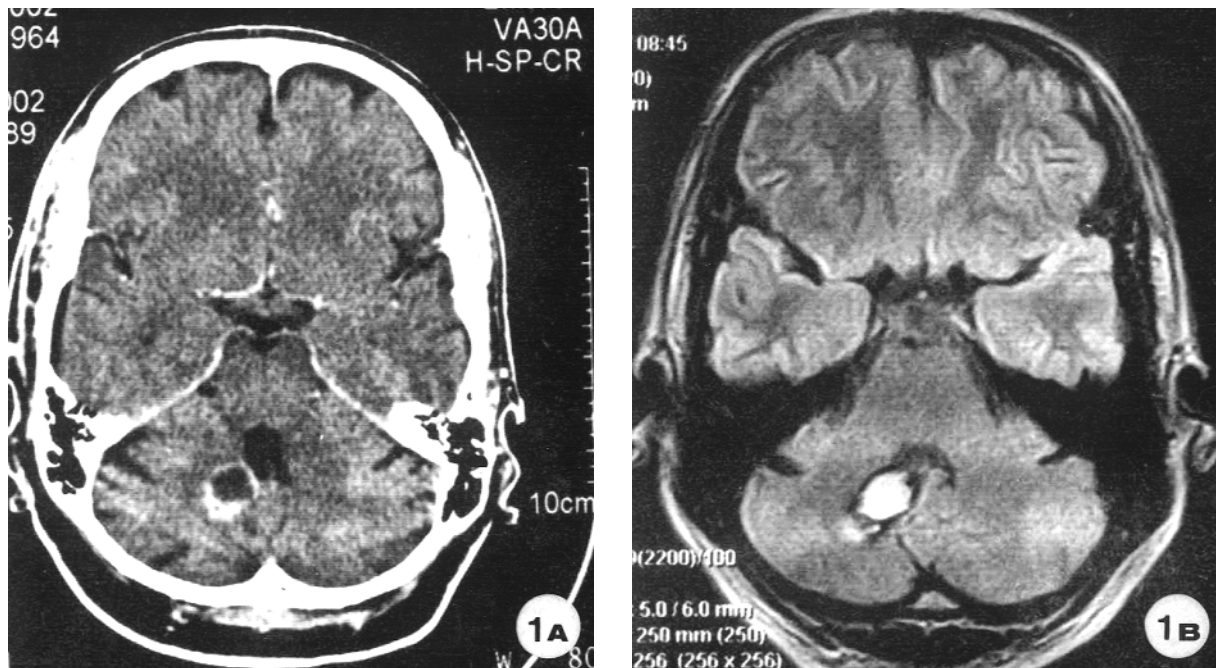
CT (A) and MRI (B) appearance of the cerebellar lesion
